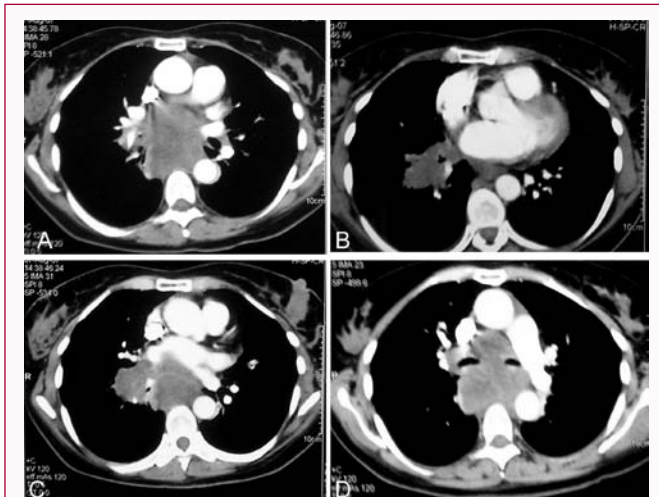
A contrast-enhanced CT of the thorax, 11/2 months after initial symptoms, revealed a solid, hypodense, 35 mm x 27 mm lung mass at the apical segment of the right lower lobe, with irregular margins and mild enhancement, that extended to the right hilum and infiltrated the right inferior pulmonary veins (A-C). An extensive mediastinal lymphadenopathy producing luminal narrowing of the trachea and the central bronchi was also observed (D).
